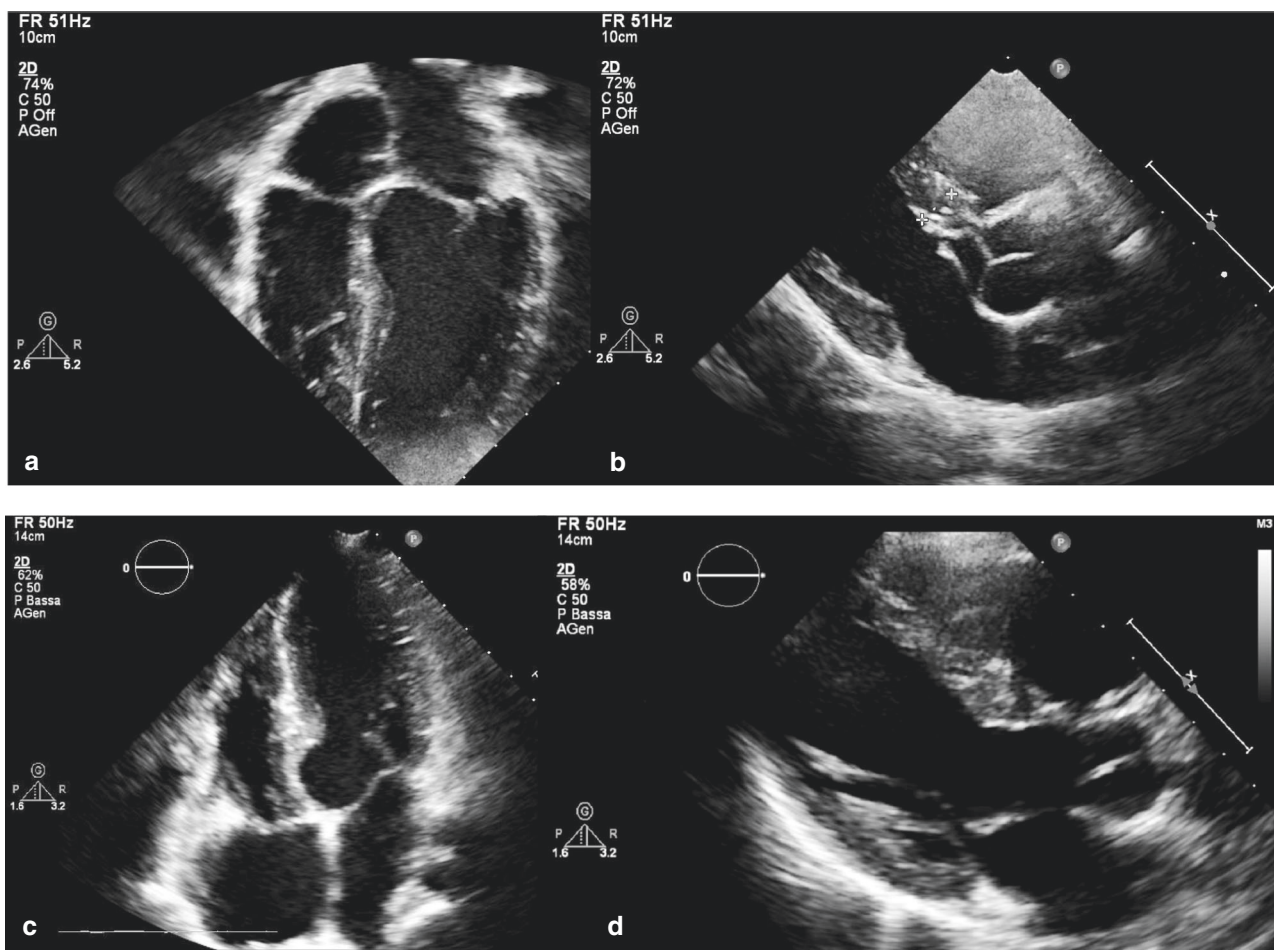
Sigmoid-shaped ventricular septum in patients with Costello syndrome and cardio-facio-cutaneous syndrome. The figure shows two examples of sigmoid-shaped ventricular septum morphology observed by echocardiography in apical 4-chamber (a, c) and parasternal long-axis (b, d) views in Costello syndrome (*HRAS*, top frames) and in cardio-facio-cutaneous syndrome (*BRAF*, bottom frames) patients. It is noteworthy that the rest of the ventricular septum is not hypertrophied in these patients.
